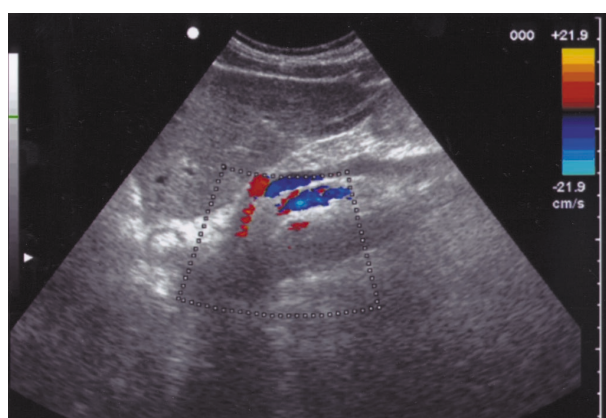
Pancreatic cancer: USG – color-Doppler – no infiltration of large vessels
